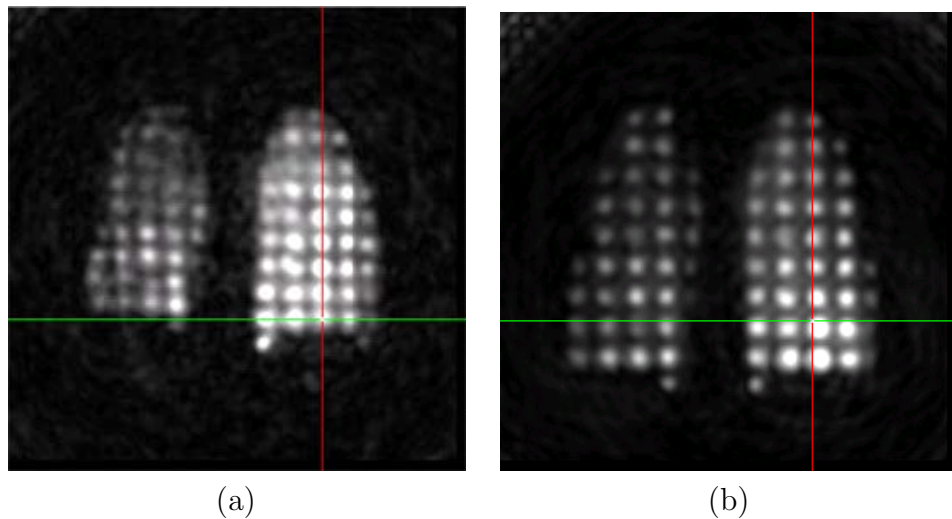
Helium-3 MRI data acquired at (a) end of exhalation and (b) end of inhalation on a coronal slice.
